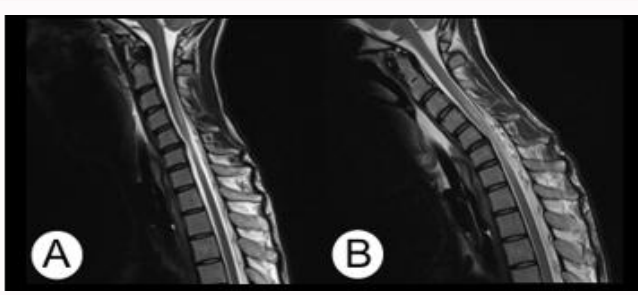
(A) Preoperative MRI neutral position. (B) Preoperative MRI flexion position.
